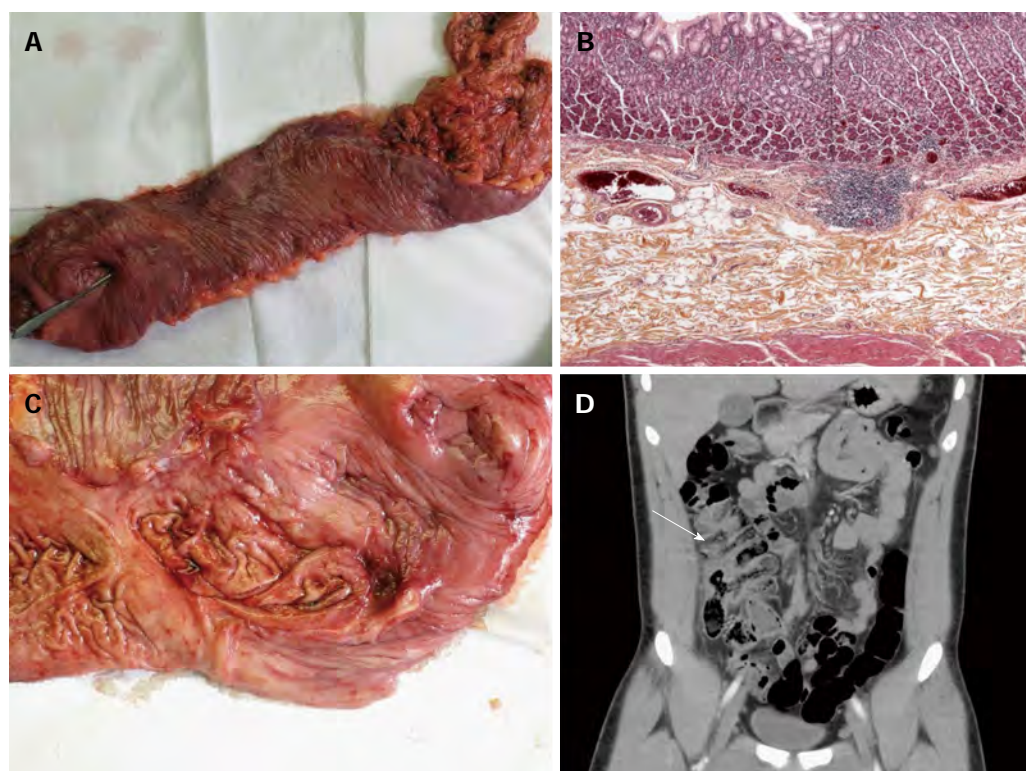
Colonic duplication. A: Macroscopic analysis of the resected colonic duplication: colonic duplication with a pen showing the anastomosis with the right colon; B: Pathological analysis of the duplication: pathological analysis showing intestinal duplication with a smooth muscle coat and an ectopic gastric mucosal lining; C: Bleeding ulcer in the colonic duplication: macroscopic view of a large bleeding ulcer near the anastomosis between the duplicated and the right colon; D: Computed tomography scan coronal view of the colonic duplication: retrospective coronal reconstruction of the emergency computed tomography scan showing the duplicated right colon (arrow) which was not visible in the axial view.
